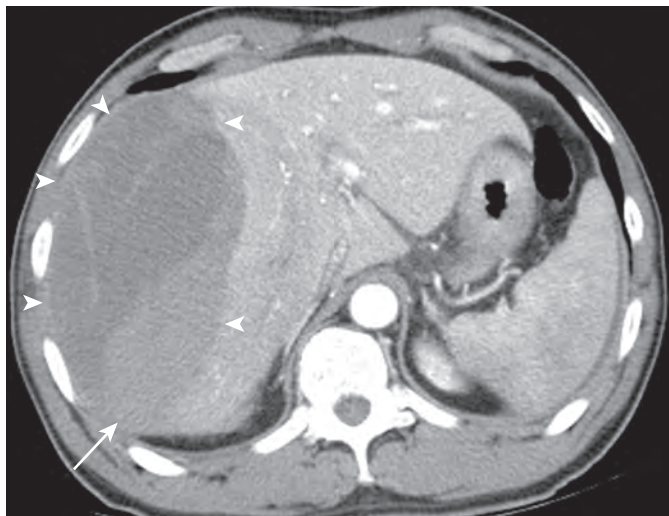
Subcapsular hematoma. A 55-year-old man was evaluated after blunt abdominal trauma. Contrast-enhanced CT scan of the abdomen reveals a subcapsular hematoma on the right hepatic lobe (arrowheads). Note the differing densities of the contents that indicate this is a hematoma, with more dense blood products along the gravity-dependent aspects of the hematoma (arrow).
